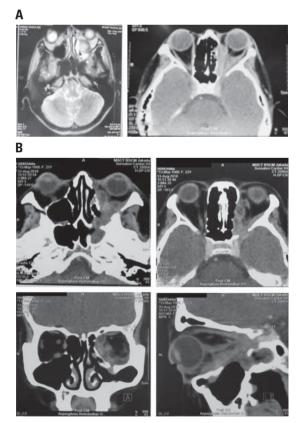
Head computed tomography of the patient at the time of admission (A) and after the administration of voriconazole (B).
